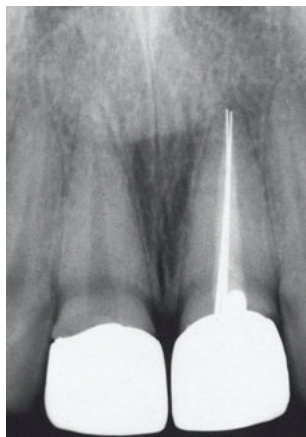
Retreatment case with a moderate degree of difficulty: due to a post-crown the coronal restoration had to be removed without damaging the silver cones. If not severely corroded (which cannot be evaluated from the radiograph), bypassing and removal should be relatively easy as there seems to be a large sealer-filled space. The type (and hardness) of the sealer or paste is unknown and therefore the ease of removal remains unclear. The internal anatomy of the root looks unchanged, therefore regaining access to the apical foramen seems feasible, all in all offering a fair prognosis for retreatment.
